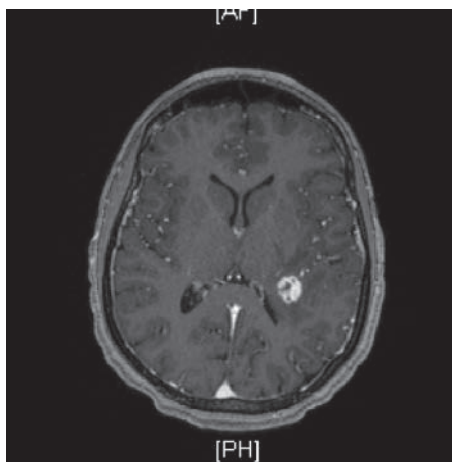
MRI of the brain. MRI showing right parietal lobe lesion with central hemorrhage.
